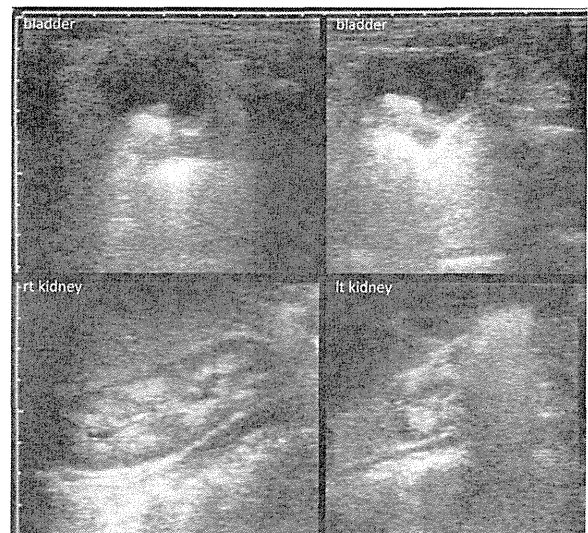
Sonography of urolithiasis. Ultrasound images of the patient at one year of age shows a 1 cm stone in the bladder and medullary calcinosis in both kidneys. Atrophy of the left kidney was diagnosed at birth.
